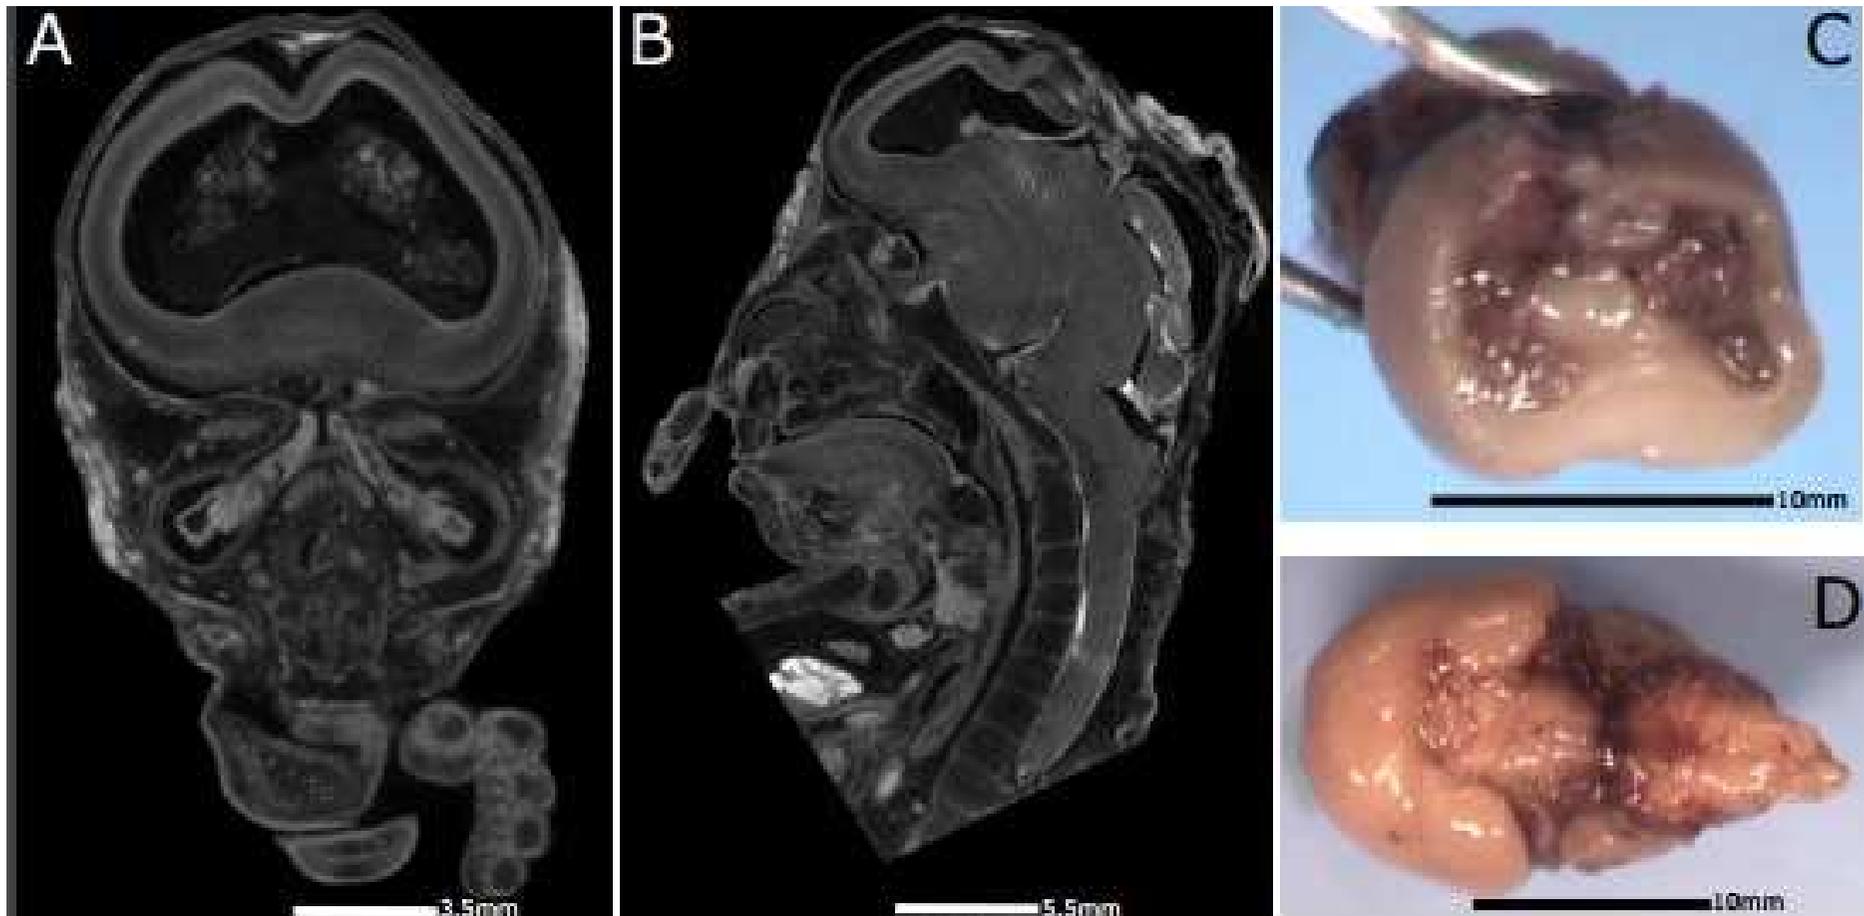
Micro CT of a 13 gestational week fetus with holoprosencephaly (case 4, A&B). Autopsy (C&D) confirmed the abnormal finding identified on micro CT.
